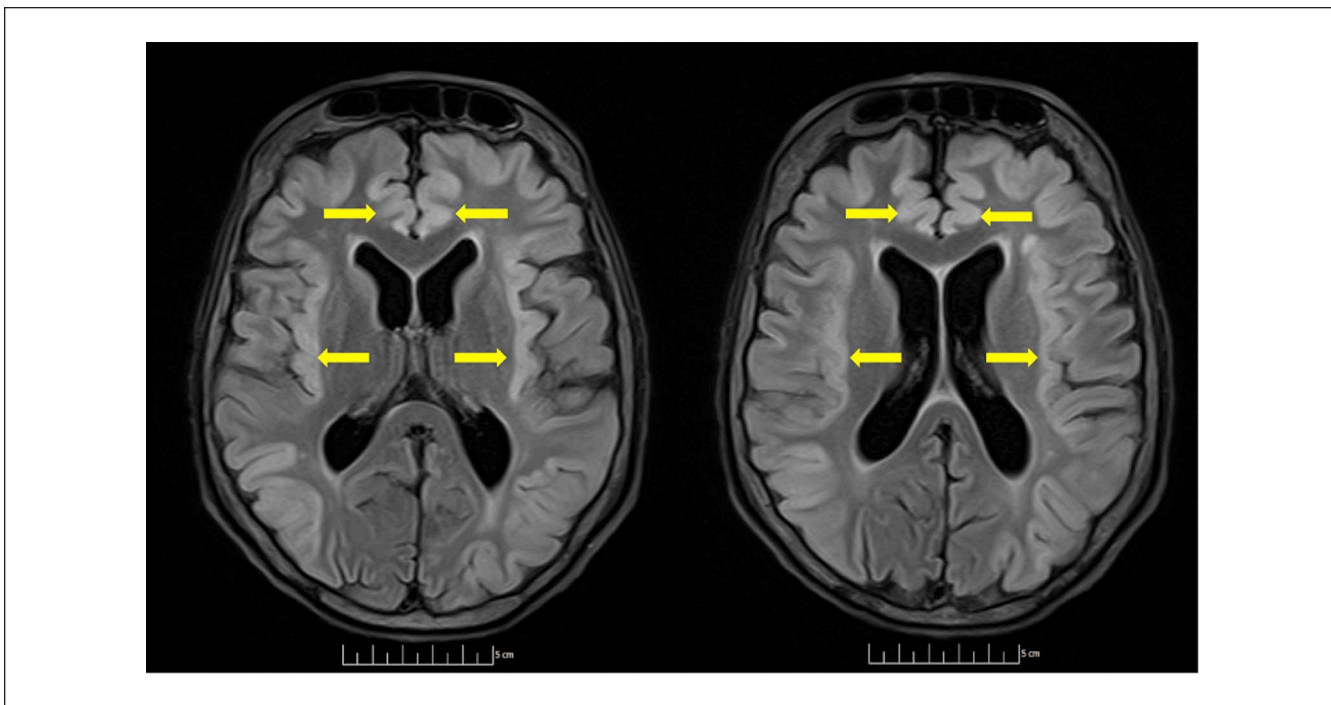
T2-Fluid Attenuated Inversion Recovery (FLAIR) images with extensive bilateral hyperintensity in the cortex, including cingulate and insular cortices (yellow arrows) typically seen with elevate ammonia levels.
